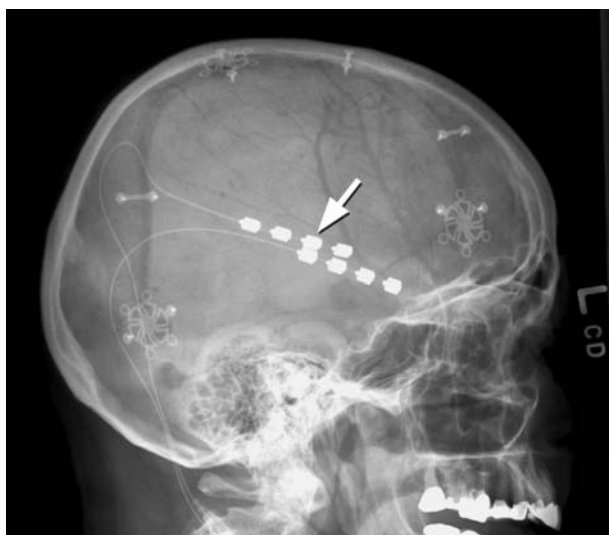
Electrical stimulation of the motor cortex provides significant pain relief in patients with intractable chronic pain. This figure is a cranial X-ray showing a lateral view of a patient with stimulating electrodes (arrow) centered over the face and arm region of the primary motor cortex. The wires from the stimulating electrodes are attached to a power source (not shown) located subcutaneously that is used to deliver the stimulating current to the electrodes.
